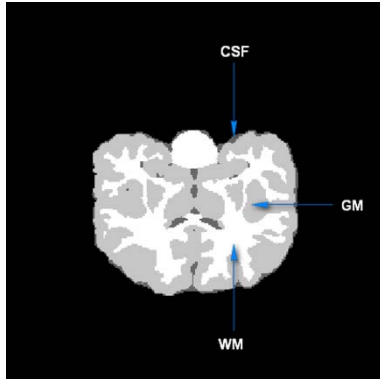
The example of WM, GM, and CSF tissues in a 2D slice brain MRI where CSF appears dark, WM appears bright, and GM appears gray
